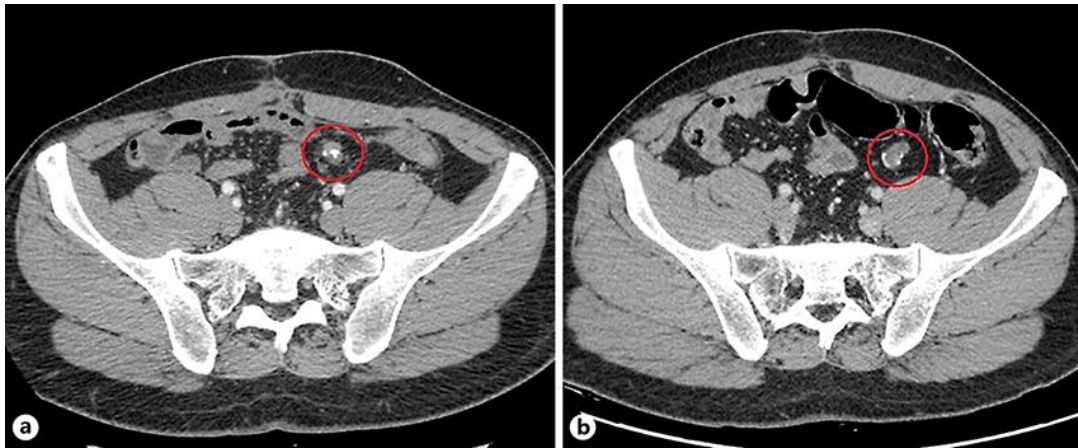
a Contrast-enhanced pelvic CT scan shows a residual formation after surgery and during postoperative chemotherapy on November 25, 2011. b Pelvic CT scan 5 years after treatment shows that the formation is stabilized (November 26, 2016).
